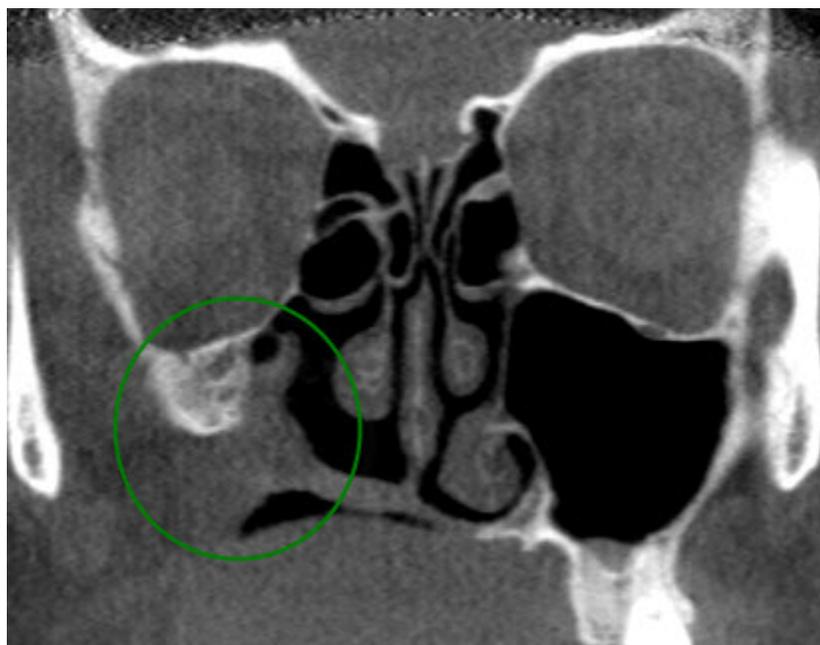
CBCT axial section showing resection of the right maxillary sinus (circle)
